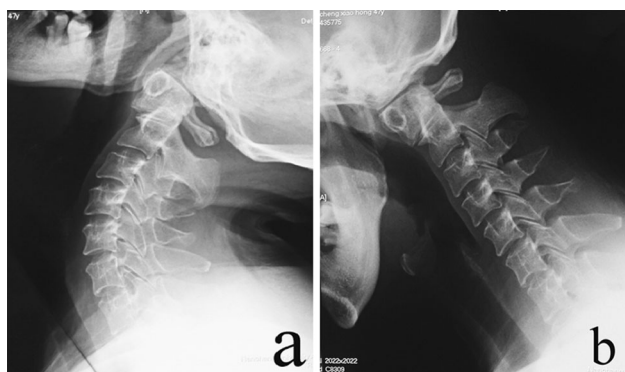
The cervical spine motion is shown in extension (a) and flexion (b) on lateral radiographs. A combined atlantooccipital and atlantoaxial articulation instability is shown
